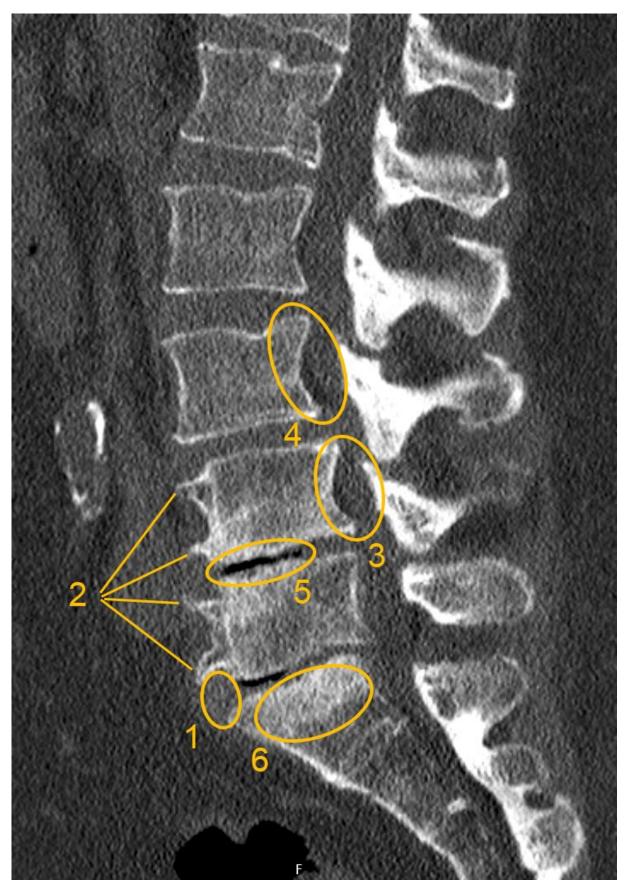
CT sagittal, showing various degenerative changes of a lumbar spine: 1. Retrolisthesis (L5-S1), 2. Spondylophytes, 3. spinal canal stenosis, 4. Corpus deformation of L3, 5. narrowing of L4 to L5 with reduced intradiscal height, 6. Sclerosis of the groundplate. (Source: Radiologie Klinikum rechts der Isar)
